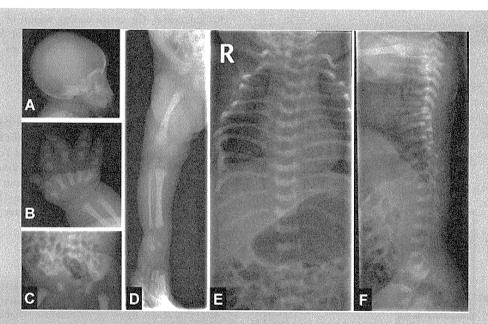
Radiographs as a neonate. A: The facial bones and skull base are mildly hypoplasitc. B: The short tubular bones are very short and bullet-shaped with "trident hand." C: The ilia are short and somewhat wide with short greater sciatic notches. D: The long bones are relatively slender without metaphyseal flaring. E,F: The thorax is narrow and anterior costal ends are cupped. There is platyspondyly with central notches. The lumbar interpediculate distance is somewhat narrow.
